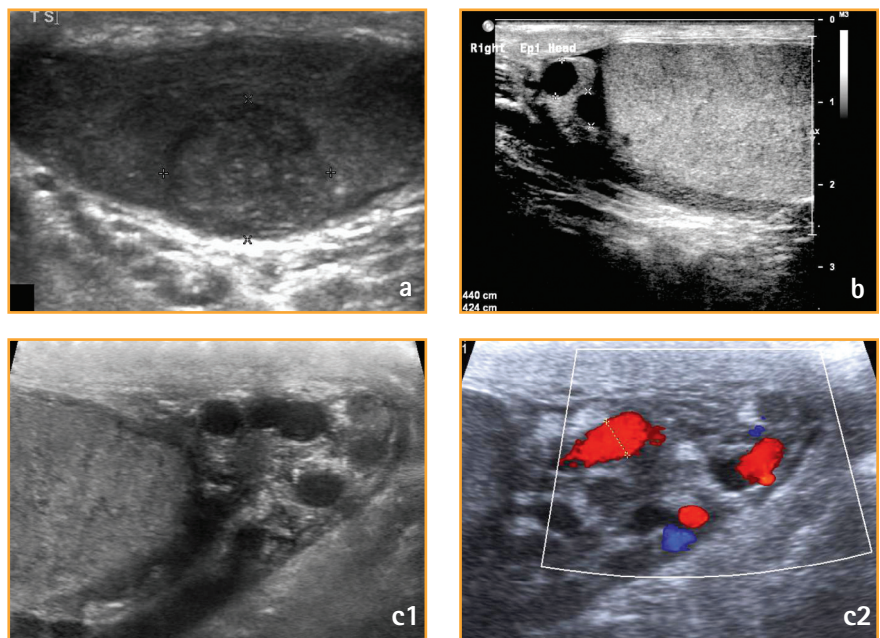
Ultrasound is a useful tool to aid clinical assessment of the patient with a scrotal mass. (a) A pT1 classical seminoma in a 30-year-old man with a previous history of undescended testes; (b) 46-year-old man with 2.4mm right epididymal head cysts; (c) 66-year-old man with left varicocele
